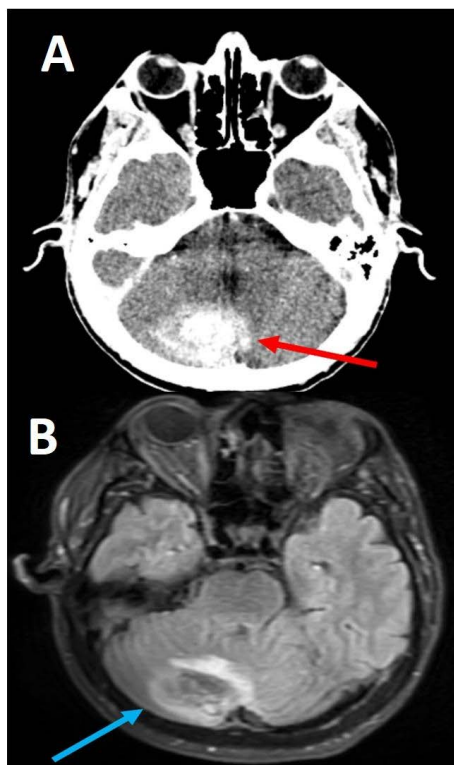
A) Brain CT Axial view and B) Brain MRI axial view with fluid-attenuated inversion recovery (FLAIR) sequence demonstrating intracerebral hematoma
